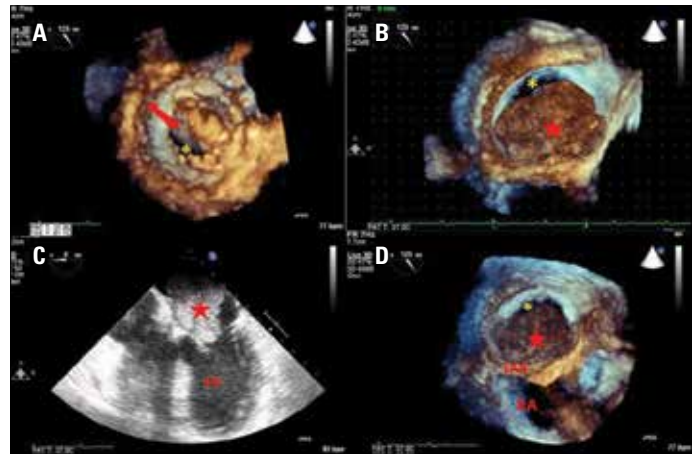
A, B, C, D) Two- and three-dimensional transesophageal echocardiography allowed to accurately imaging the entire volume of the myxoma (arrow,★), and to analyze the dynamic left ventricular inflow obstruction (*)
